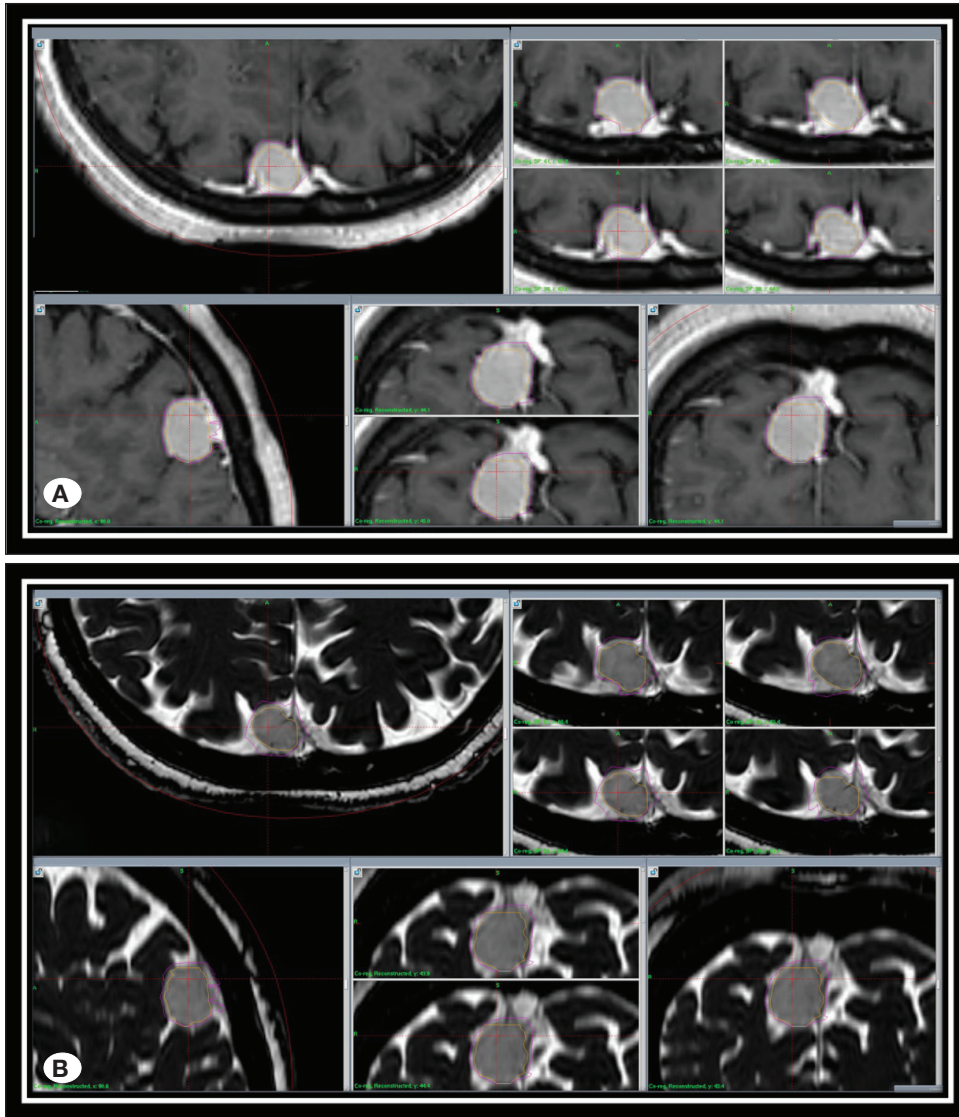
A) The purple line represents the right parasagittal meningioma border determined by T1 contrast-enhanced MRI for GKRS. B) The yellow line represents the right parasagittal meningioma border in the same section of the same tumor on FIESTA sequence MRI.
